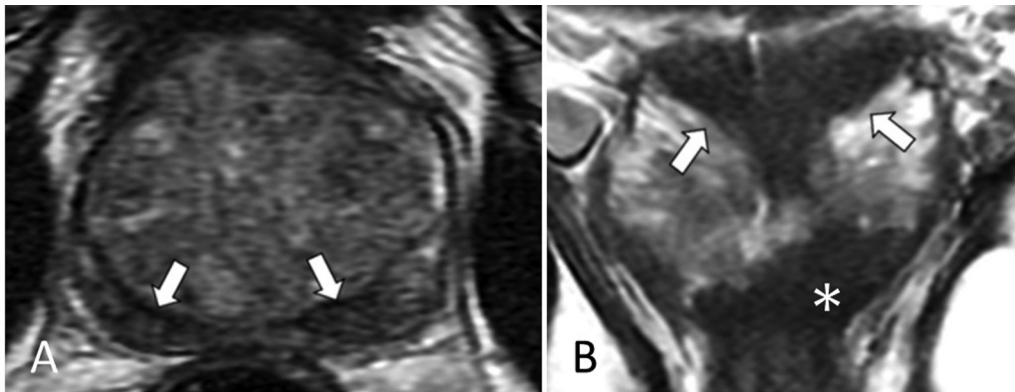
“Mustache” sign (A – axial sections), the compressed central zone (CZ) appearing as symmetric, bilateral areas of low signal intensity on T2-weighted image (T2WI) at the base surrounding the ejaculatory ducts. “Teardrop” sign (B – coronal sections), the compressed CZ presenting as a median low signal intensity area at the middle third, extending up to the level of the verumontanum inferiorly. Carcinoma seen as ill-defined T2 hypointense lesion in the peripheral zone in the apex (asterisk).
